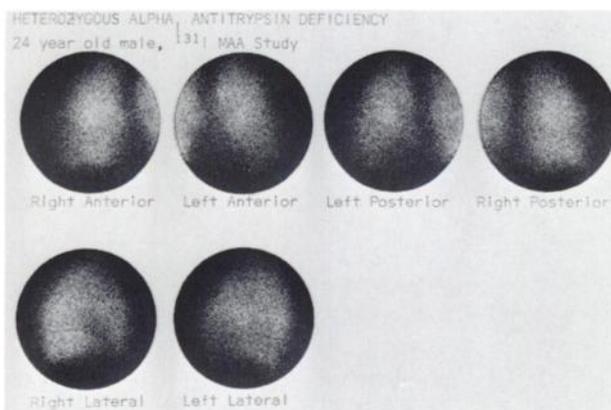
Perfusion images of asymptomatic heterozygote who had normal pulmonary function ($FEV_1 = 90\%$ of FVC) and chest x-rays. Irregular labeling is seen throughout both lung fields, suggesting generalized changes in small pulmonary vessels.
